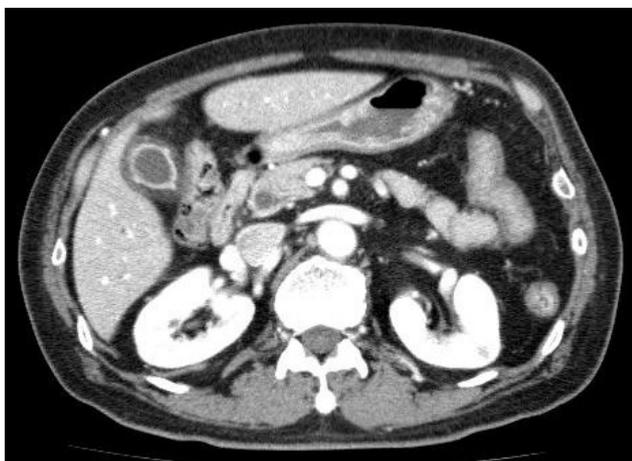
Diffuse GB wall edema with pericholecystic fluid collection and subtle calcification in the CBD were noted in the abdominal CT scan. GB, gallbladder; CBD, common bile duct; CT, computed tomography.
